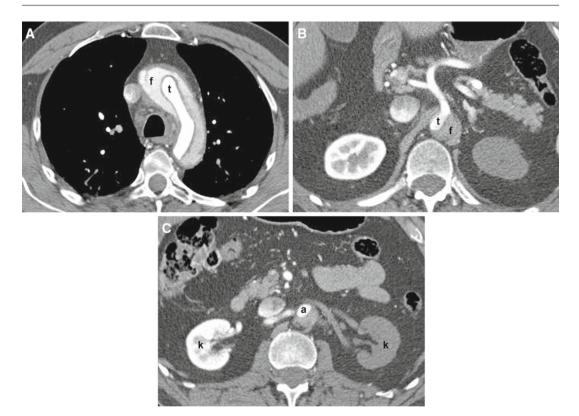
Images of a TAD. A 60-year-old man presents to the emergency department with the acute onset of severe thoracolumbar back pain. A CT scan showed Stanford type A and DeBakey type I thoracic aortic dissection which extended from the aortic valve to the aortic bifurcation. A CT image (A) at the aortic arch shows differential opacification of the true (t) and false (f) lumina.
